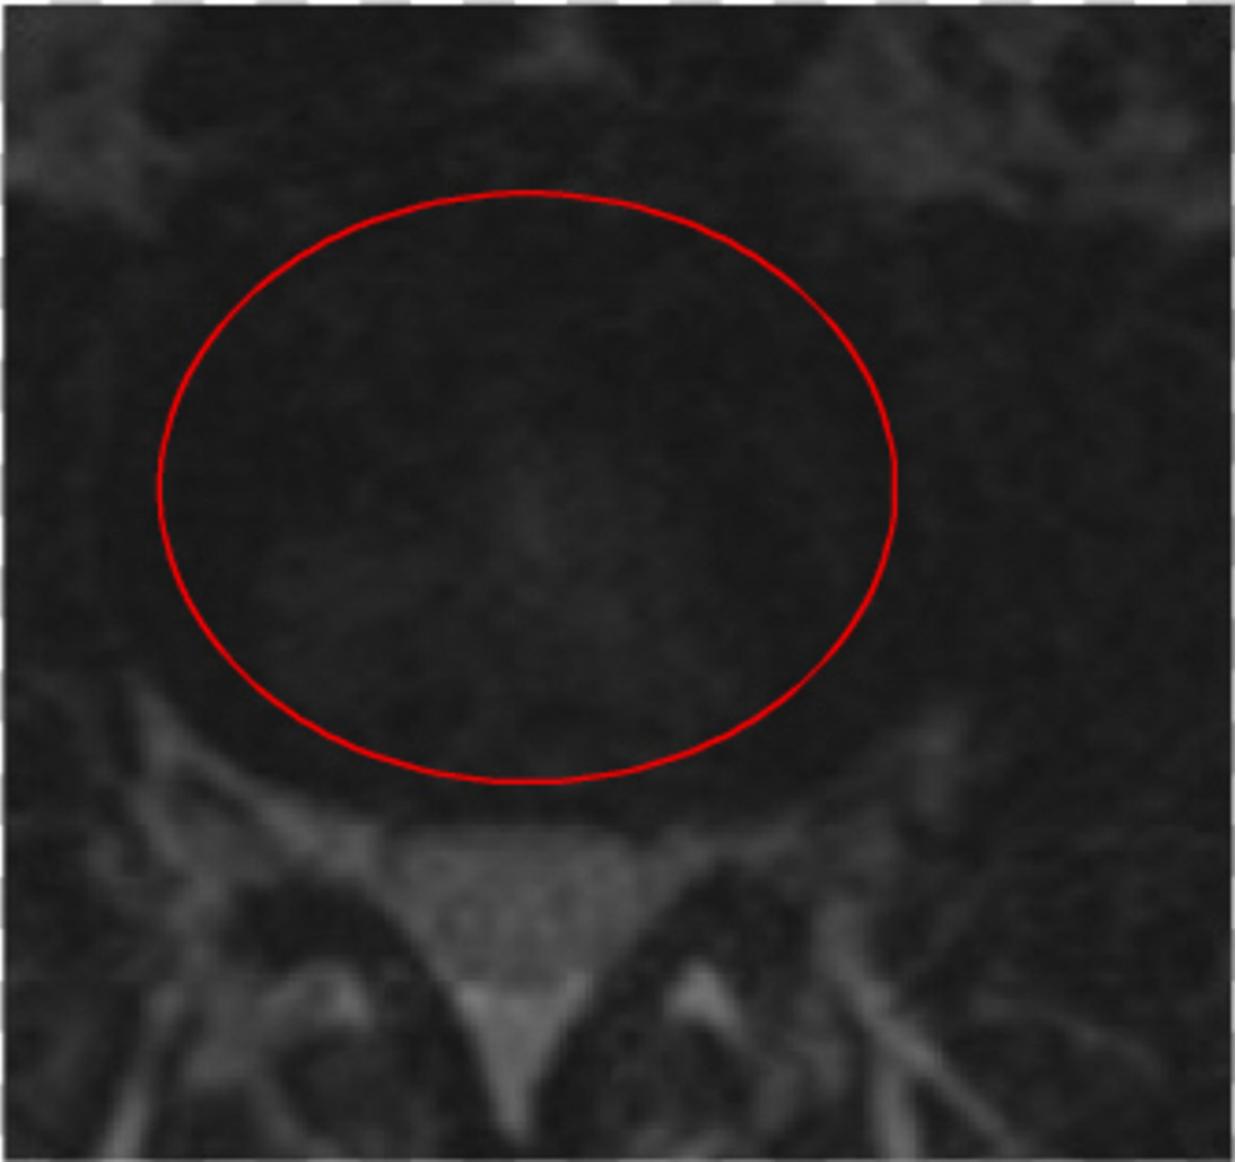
Axial T2 Weighted Lumbar Spine MRI. Symmetrical Disc Bulge
